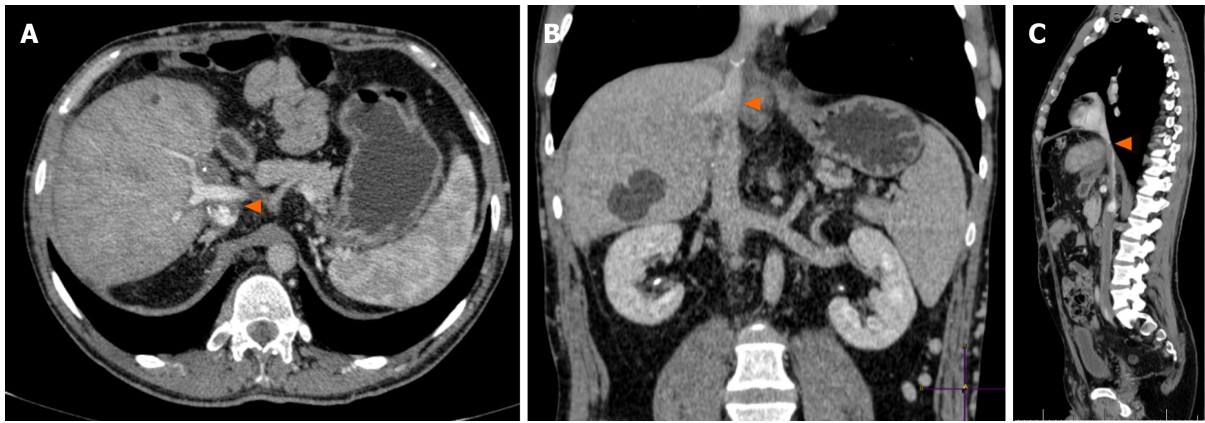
Late postoperative abdominal computed tomography scan, portal phase. A: Graft with adequate aspect and preserved portal inflow (arrowhead); B: Coronal view showing patent retrohepatic vena cava (arrowhead) and preserved graft outflow; C: Sagittal view of patent retrohepatic vena cava (arrowhead).
